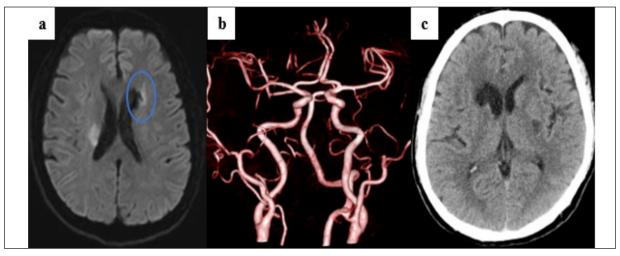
The first case. a, Diffusion-weighted imaging (DWI) shows new infarcts in the left posterior limb of the internal capsule and near the left lateral ventricle (blue circle). b, Magnetic resonance angiography (MRA) shows no left LVO in the anterior circulation. c, The postoperative computed tomography (CT) scan did not indicate intracranial hemorrhage.
